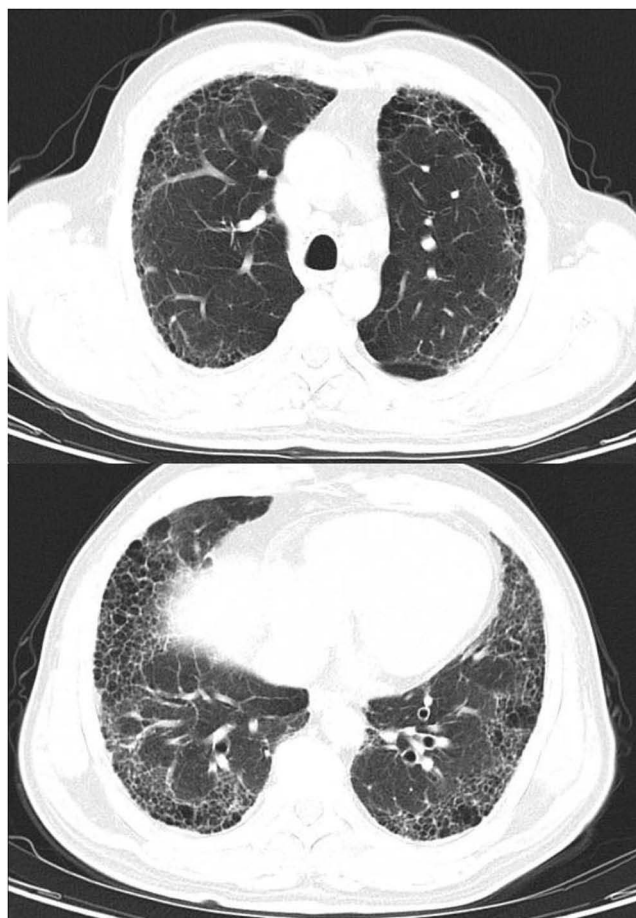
HRCT findings of Case 2 (2023-11-29). Top image: Interstitial changes in both lungs, emphysema, and bullae in both upper lungs with fine reticular shadows. Bottom image: More pronounced reticular shadows and interlobular septal thickening in both lower lungs.
